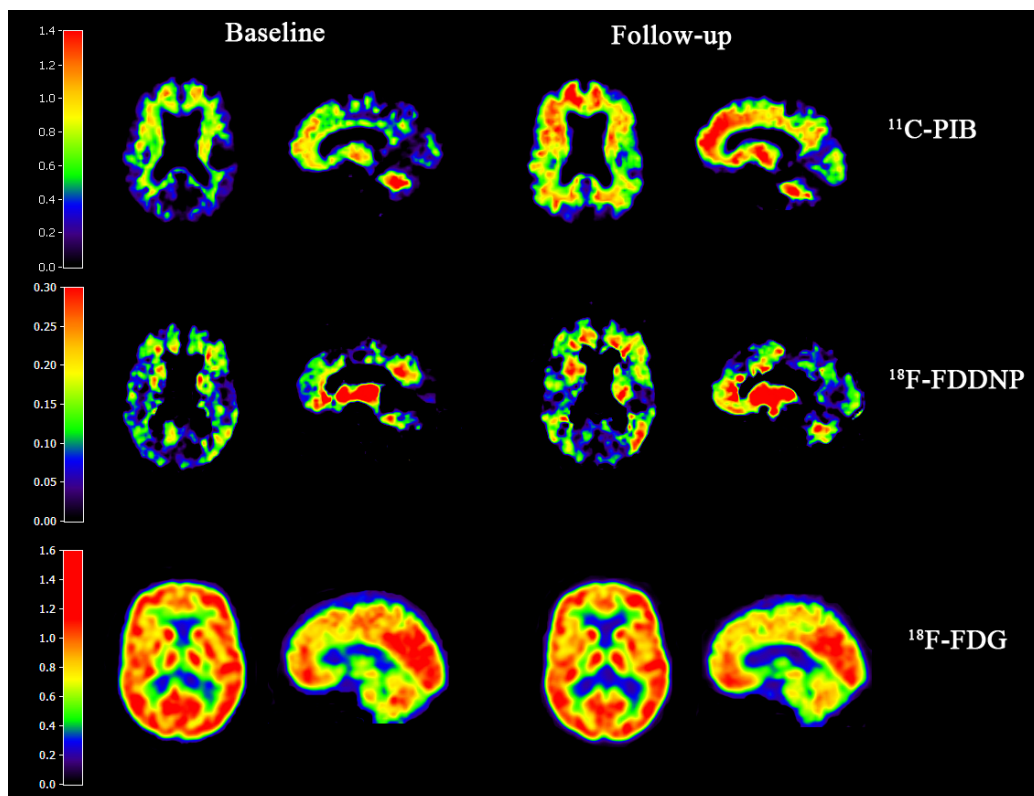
Baseline and follow-up parametric $[^{11}\text{C}]\text{PIB}$ BP_{ND} (upper row) and $[^{18}\text{F}]\text{FDDNP}$ BP_{ND} (middle row) and $[^{18}\text{F}]\text{FDG}$ SUVr (lower row) images of a patient with mild cognitive impairment, who did not convert to AD during the follow-up period. The $[^{11}\text{C}]\text{PIB}$ PET scans show a clear shift from predominantly non-specific binding in subcortical structures at baseline towards generalized cortical binding at follow-up. The latter pattern typically is observed in patients with Alzheimer's disease. In addition, the $[^{18}\text{F}]\text{FDDNP}$ scans of this patient display increased cortical binding over time. The $[^{18}\text{F}]\text{FDG}$ scans show minor longitudinal changes but both baseline and follow-up scans are within the normal range. Longer follow-up is needed to determine whether the increased amyloid burden eventually will lead to progression to AD.
